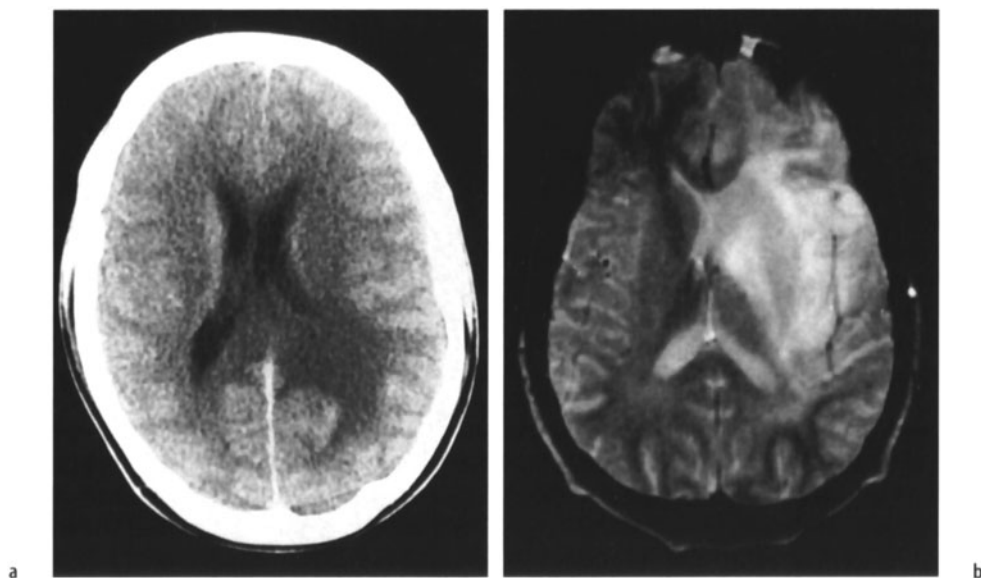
Fibrillary astrocytoma on a computed tomography (CT) and b magnetic resonance imaging (MRI)
